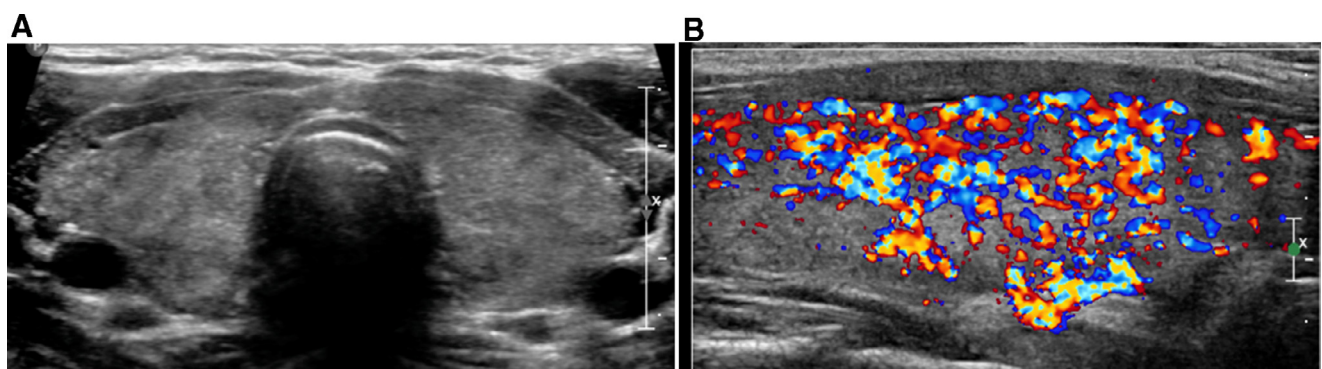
Graves disease. Fourteen-year-old girl presenting with weight loss, fatigue, elevated thyroid hormone levels, and TSH suppression. A. Transverse gray scale ultrasound image shows an enlarged and heterogeneous gland. B. Sagittal color Doppler ultrasound image demonstrates increased vascularity.
